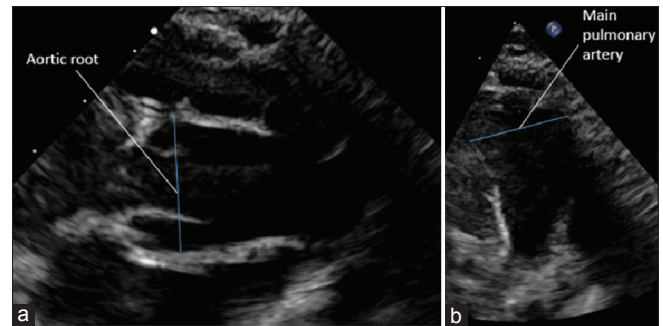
Transthoracic echocardiogram demonstrating dilated (a and b) ascending aorta, (c) main pulmonary artery and (d) aortic root at 3 months of age
